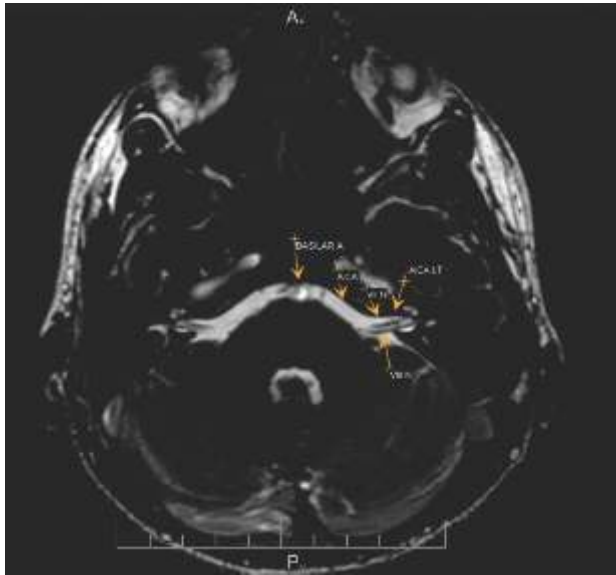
MRI 3D-FIESTA sequence demonstrating type III variant of AICA (on the left) as it passes into the IAM for more than 50% of its length, crossing over VII/VIII nerves
